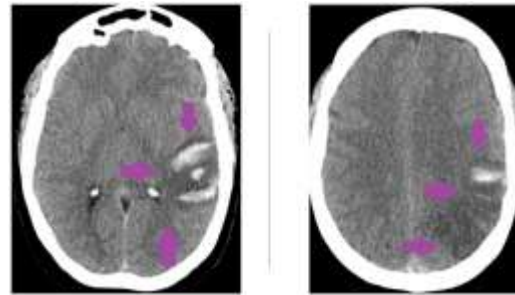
Axial non-contrast CT image showing areas of hyperdensity (blood) within areas of regional hypodensity (ischemia) (purple arrows).
